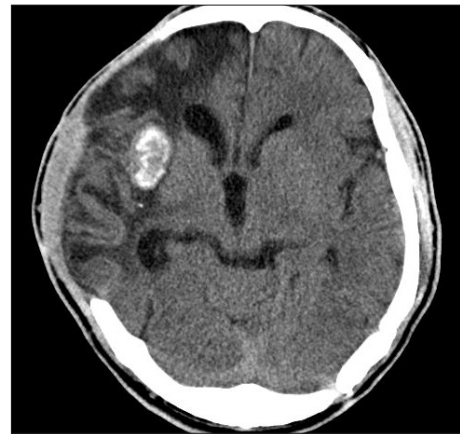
After navigation-guided drainage of the abscess, CT scan performed 5 months after admission show calcified brain abscess.
